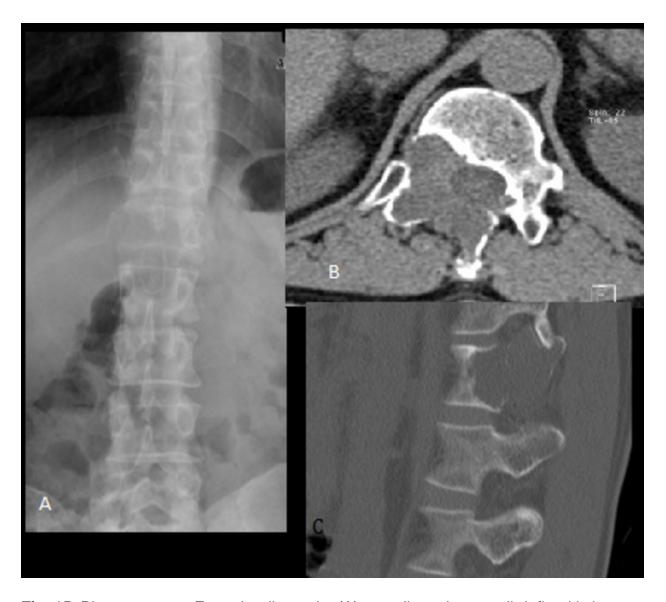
Plasmacytoma. Frontal radiography (A) revealing a large well-defined lytic lesion in the first lumbar vertebra. Axial (B) and sagittal (C) computed tomography images allows better extension and cortical disruption assessment. References: Serviço de Imagem Médica, Centro Hospitalar e Universitário de Coimbra, Faculdade de Medicina de Coimbra Medical Imaging Department and Faculty of Medicine, University Hospital of Coimbra, Portugal CT
